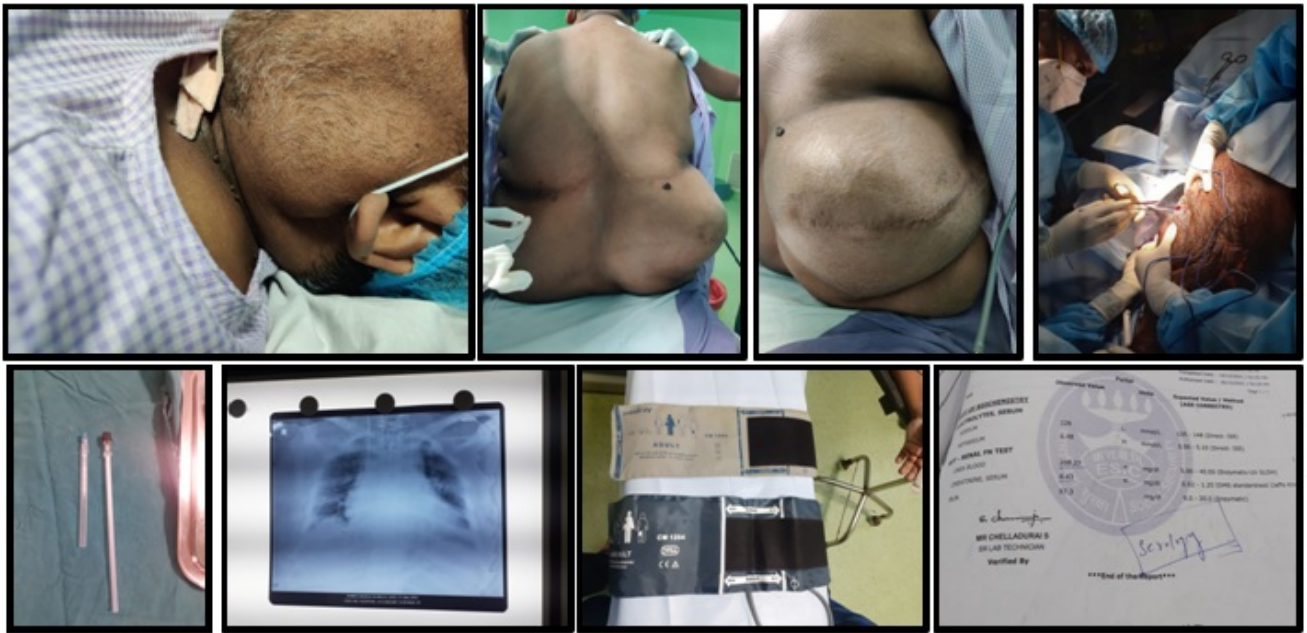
Serial images showing super obesity with curved spine, sacral edema, difficult spinal anaesthesia administration, longer spinal needle, chest x-ray showing cardiomegaly with cardiogenic pulmonary edema, larger Blood pressure cuff and deranged renal function tests
